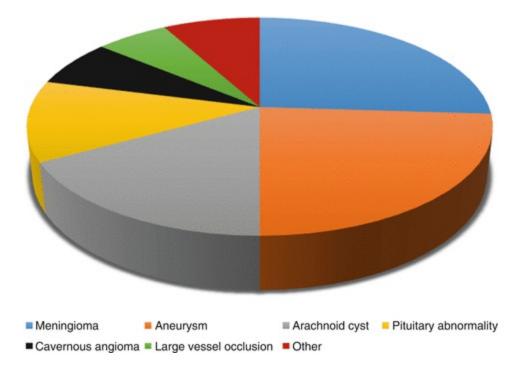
Pie chart on the frequency of incidental findings on brain MRI in the Rotterdam Study. The section "Other" includes vestibular schwannoma, arteriovenous malformation, dural fistula, possible glioma, trigeminal schwannoma, orbital dermoid cyst, fibrous dysplasia, intracranial lipoma, atypical cerebellar lesion, ganglioglioma, subependymoma, metastasis, pineocytoma, pharyngeal mucosal asymmetry, colloid cyst of the third ventricle, and expansive lesion in the maxillary sinus
